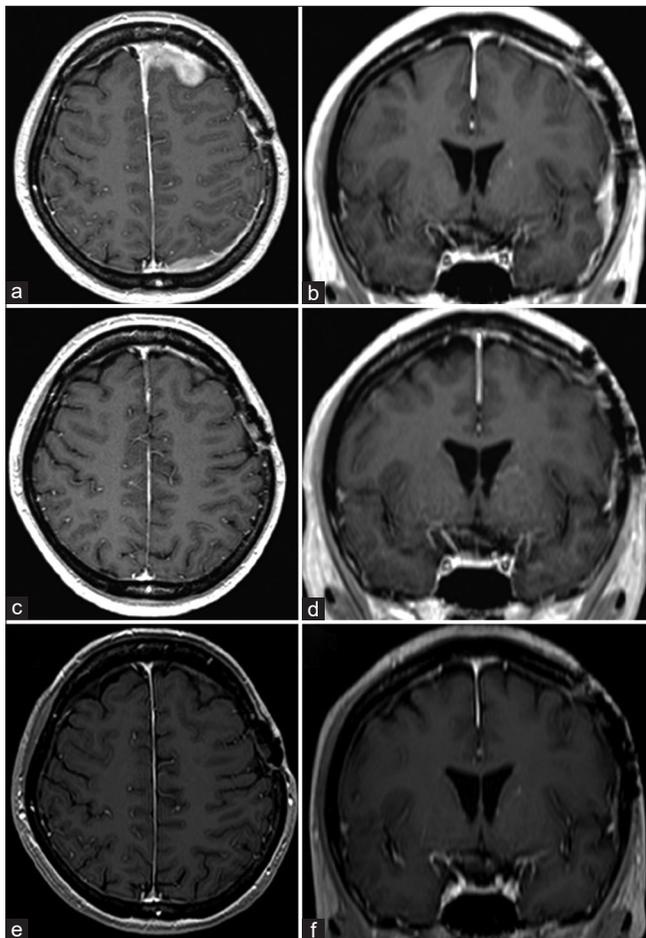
Preradiotherapy magnetic resonance imaging (MRI). Axial (a) and coronal (b) MRI with gadolinium contrast show residual contrast-enhancing extra-axial masses in the left frontal, temporal, and parietal lesions. The thickening and enhancement of the dura extend along the falx and the left frontal and parietal lobes. MRI at three months after radiation therapy. Axial (c) and coronal (d) MRI with gadolinium contrast indicate the disappearance of residual contrast-enhancing extra-axial masses in the left frontal, temporal, and parietal lesions and normalization of the dural thickening and enhancement. MRI at eight months after radiation therapy. Axial (e) and coronal (f) MRI with gadolinium contrast reveal no recurrence.
